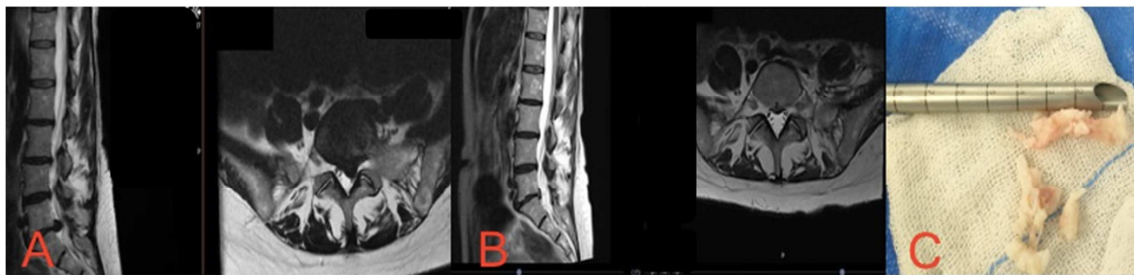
a) MRI T2 axial and coronal showing large left sided extruded disc material causing left sciatica. b) MRI T2 axial and coronal showing postoperative showing well decompression c) Large fragment extracted by endoscope.
